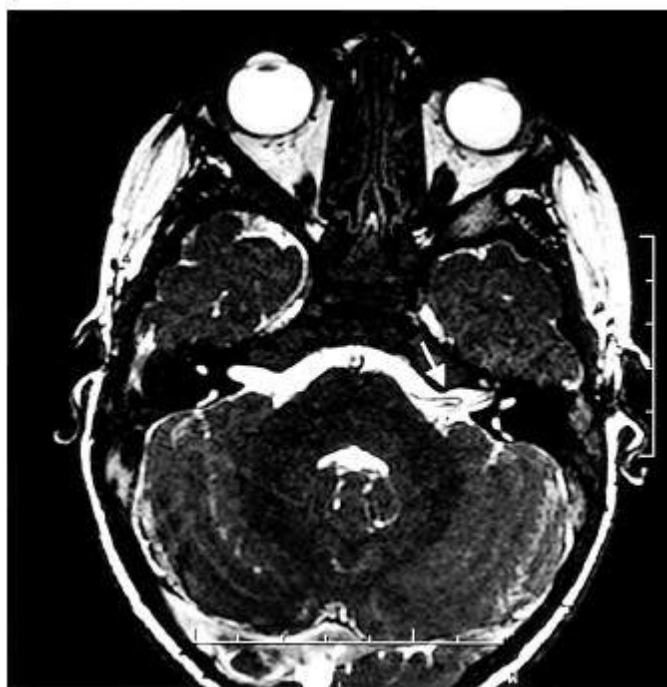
T2-weighted magnetic resonance imaging scan showing the loop of the anterior inferior cerebellar artery impinging on the VIIth nerve (arrow).
